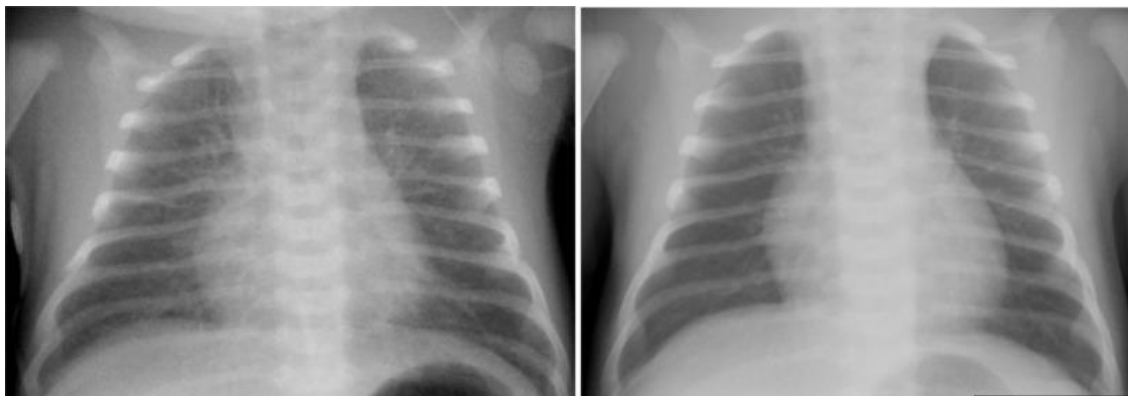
Chest Radiography, left TTN, right healthy subject (LearningRadiology).
